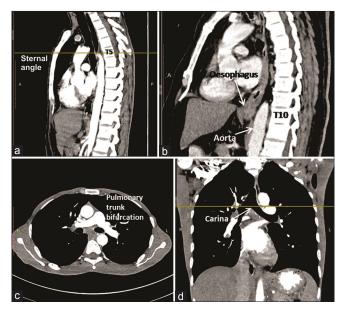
Computed tomography images showing (a) Vertebral level of the sternal angle (T5) identified in sagittal scan. (b) Vertebral level at which the esophagus and aorta passed through or behind the diaphragm determined in sagittal projections. (c) Pulmonary trunk bifurcation identified in axial scans. (d) Carina of tracheal bifurcation identified in coronal scans. (T, Thoracic vertebra)
